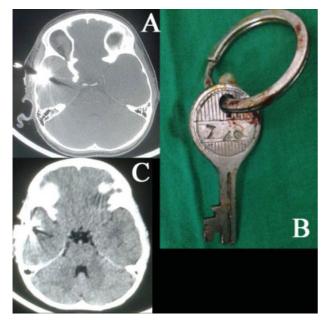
(A and C) computed tomographic scan of brain with bone window, (B)key after removing from the skull.
